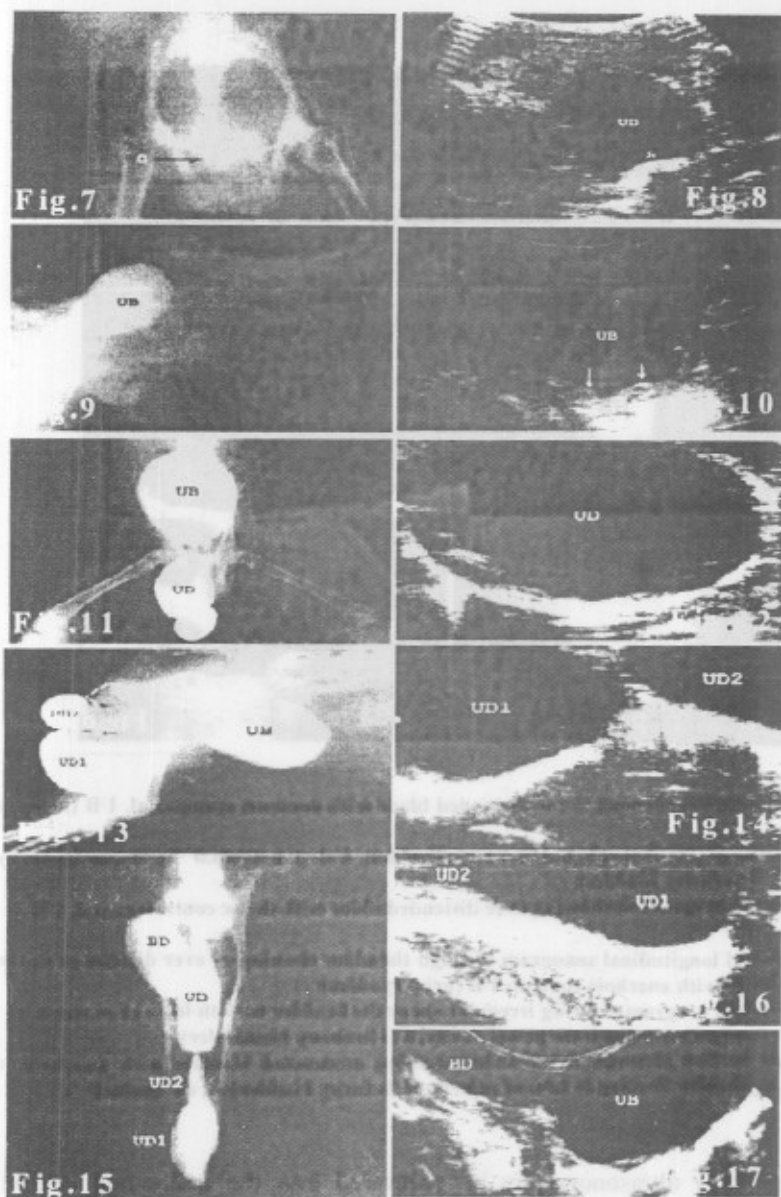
Ventrodorsal survey radiograph showing radiopaque stones in the most dependant part of the pelvic cavity. S (stone)
